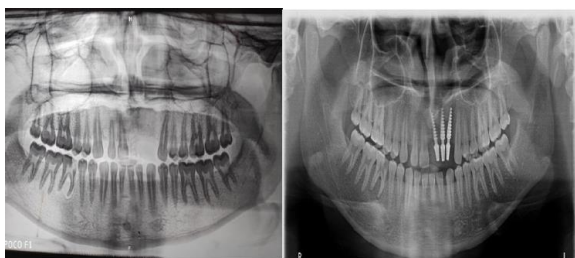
Preoperative and post operative orthopantomogram.
